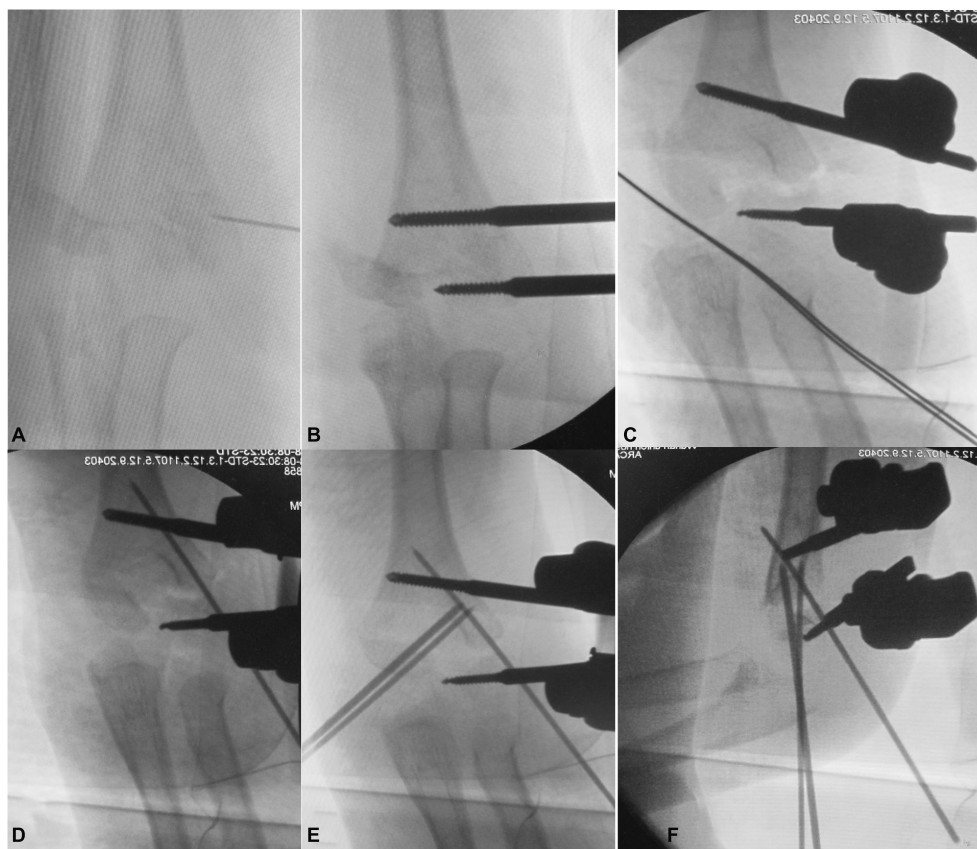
The C-arm x-ray during operation showed: (A) the distal lateral condyle fragment located with a syringe needle; (B) placement of radial unilateral external fixation; (C) reset the lateral side of the distal humerus by closed reduction and tightened external fixation; (D) placement of the radial side anti-rotation K-wire to stable the lateral fragment; (E) placement of the ulnar K-wire to stable the medial fragment; (F) lateral view of the elbow after fixation.
